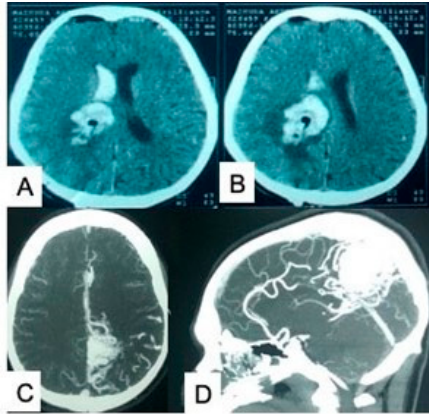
(A,B) CT scan of the brain showing an intraventricular along with a medial parietal bleed. (C,D) CT angiogram revealed a compact medial parietal (paracentral lobule) AVM fed by branches from the pericallosal artery and venous draining toward the superior sagittal sinus. Source: Figure by authors.
